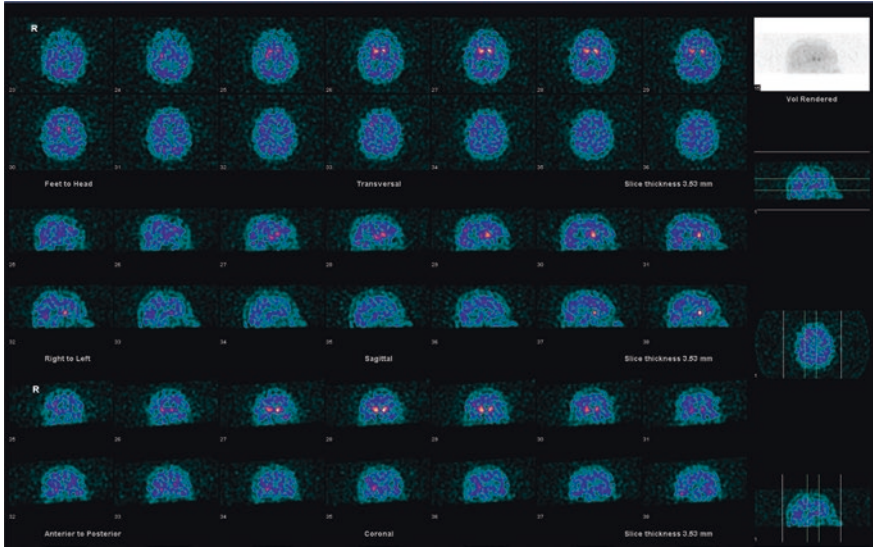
SPECT DAT brain imaging in an 80-year-old male patient with clinical signs of Parkinson syndrome. The striatum demonstrates abnormally reduced uptake bilaterally, most pronounced in the posterior striatum. Findings are in keeping with neurodegenerative parkinsonism
